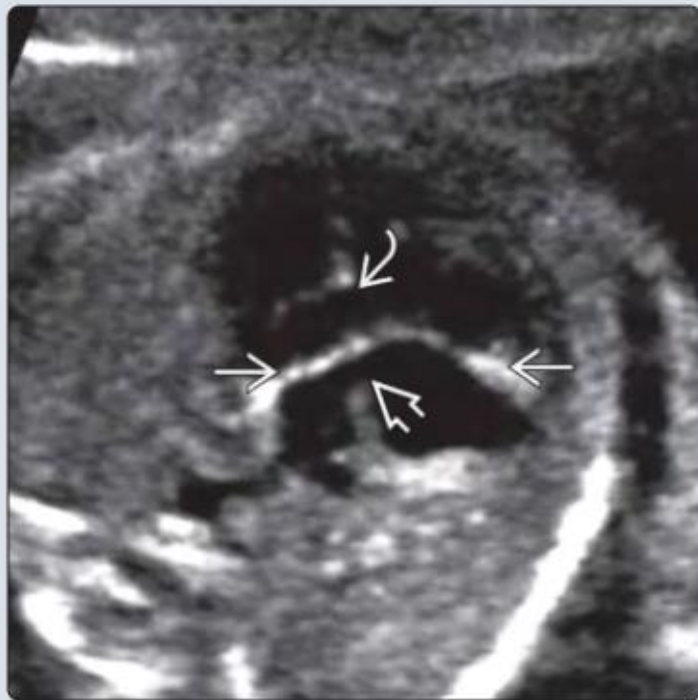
Atrioventricular septal defect. Sonographic findings for a complete atrioventricular septal defect consist of atrial septal defect (asd), ventricular septal defect (vsd), and lack of the normal offset atrioventricular valve insertion sites. The common valve appears as a straight echogenic line.
